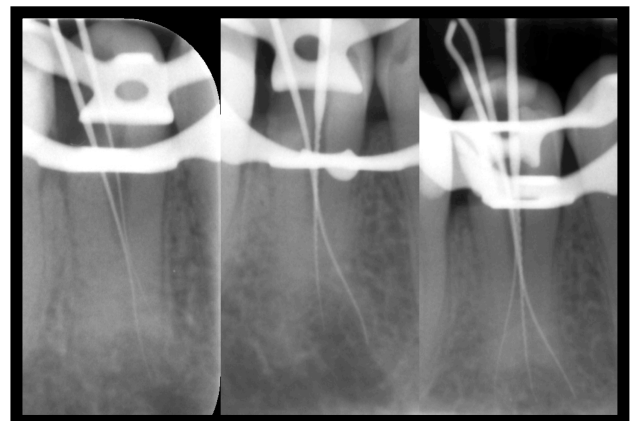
Working length radiographs. Left, middle: First visit; Right: Last visit
